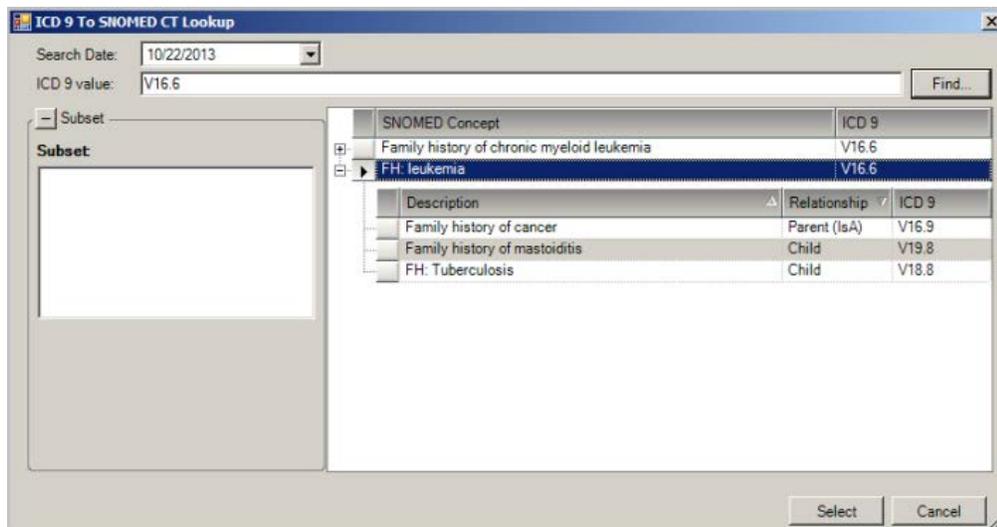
ICD 9 to SNOMED CT Lookup dialog
